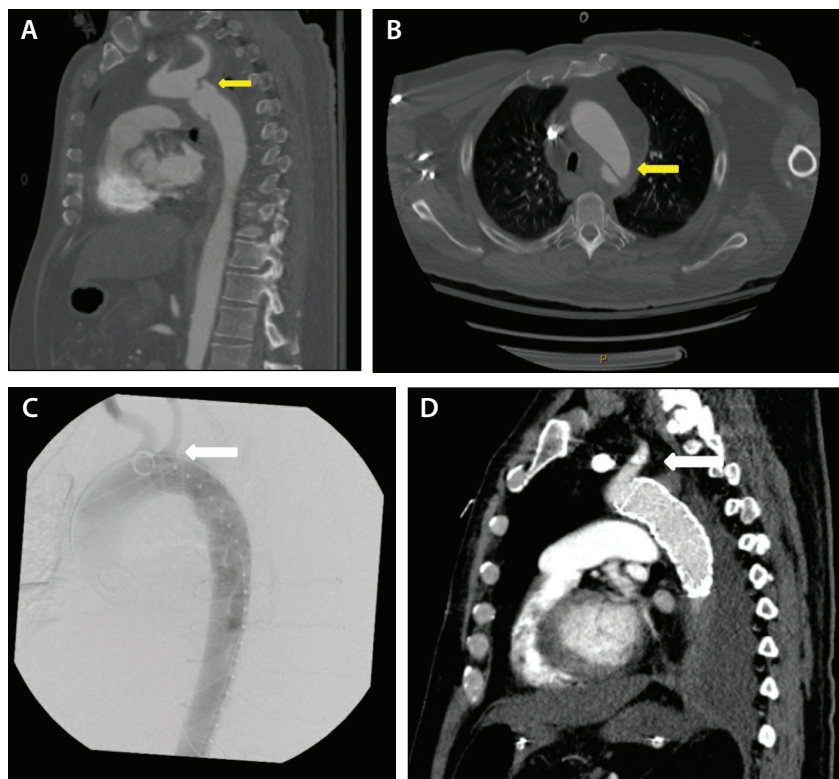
Blunt traumatic disruption of the descending thoracic aorta in a 63-year-old man directly adjacent to the LSA. CTA showed extensive mediastinal hematoma and complete intimal separation (yellow arrows) (A, B). Subclavian artery coverage with stent graft landing just beyond the left common carotid artery was necessary. Carotid preservation was seen on intraoperative completion angiogram and follow-up CTA (white arrows; C, D).
